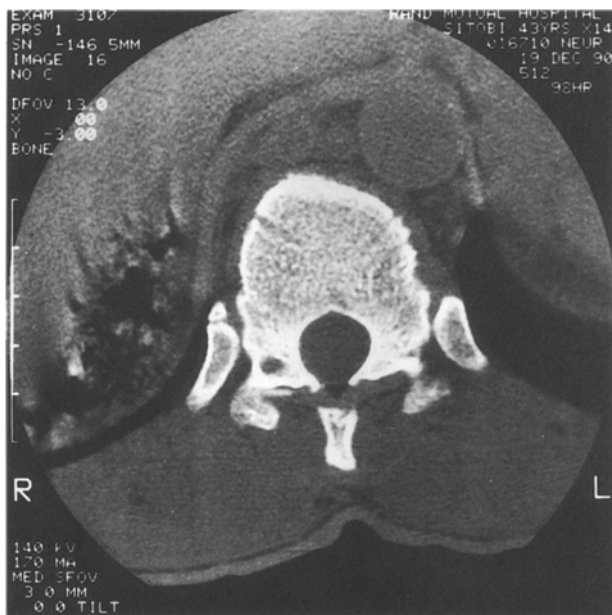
An isolated tuberculous focus in the right pedicle demonstrated by CT. The patient presented with paraplegia and incontinence
